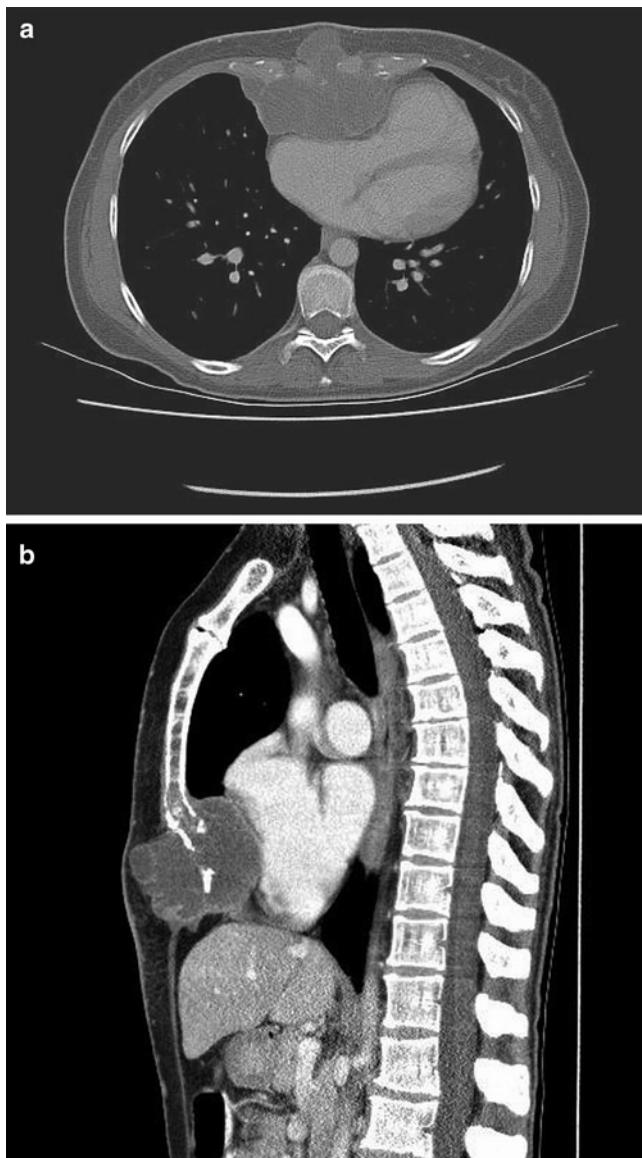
Transverse (a) and saggital (b) CT scan views of a patient with a chondrosarcoma of the lower sternum. The tumor is compressing the right ventricle.
